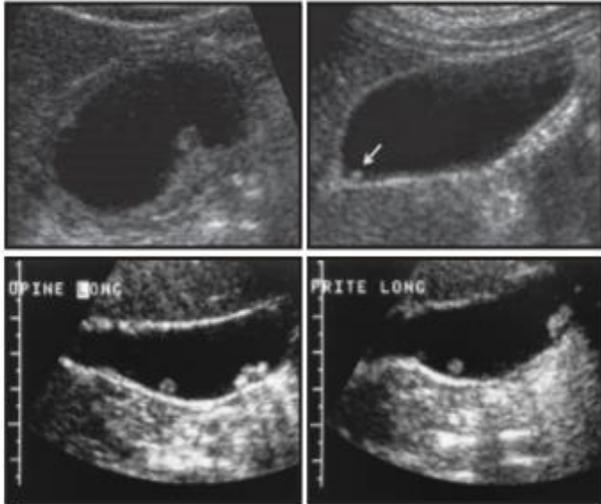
Ultrasound Showing GB Polyp
